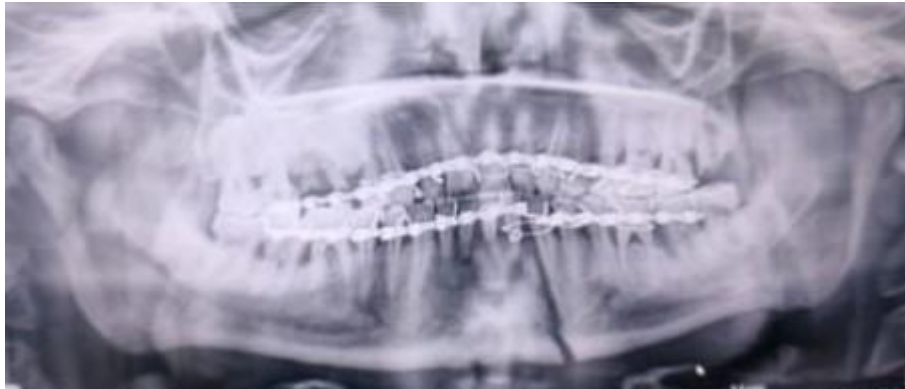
showing orthopantomogram revealing left parasymphysis fracture and right subcondyl fracture
